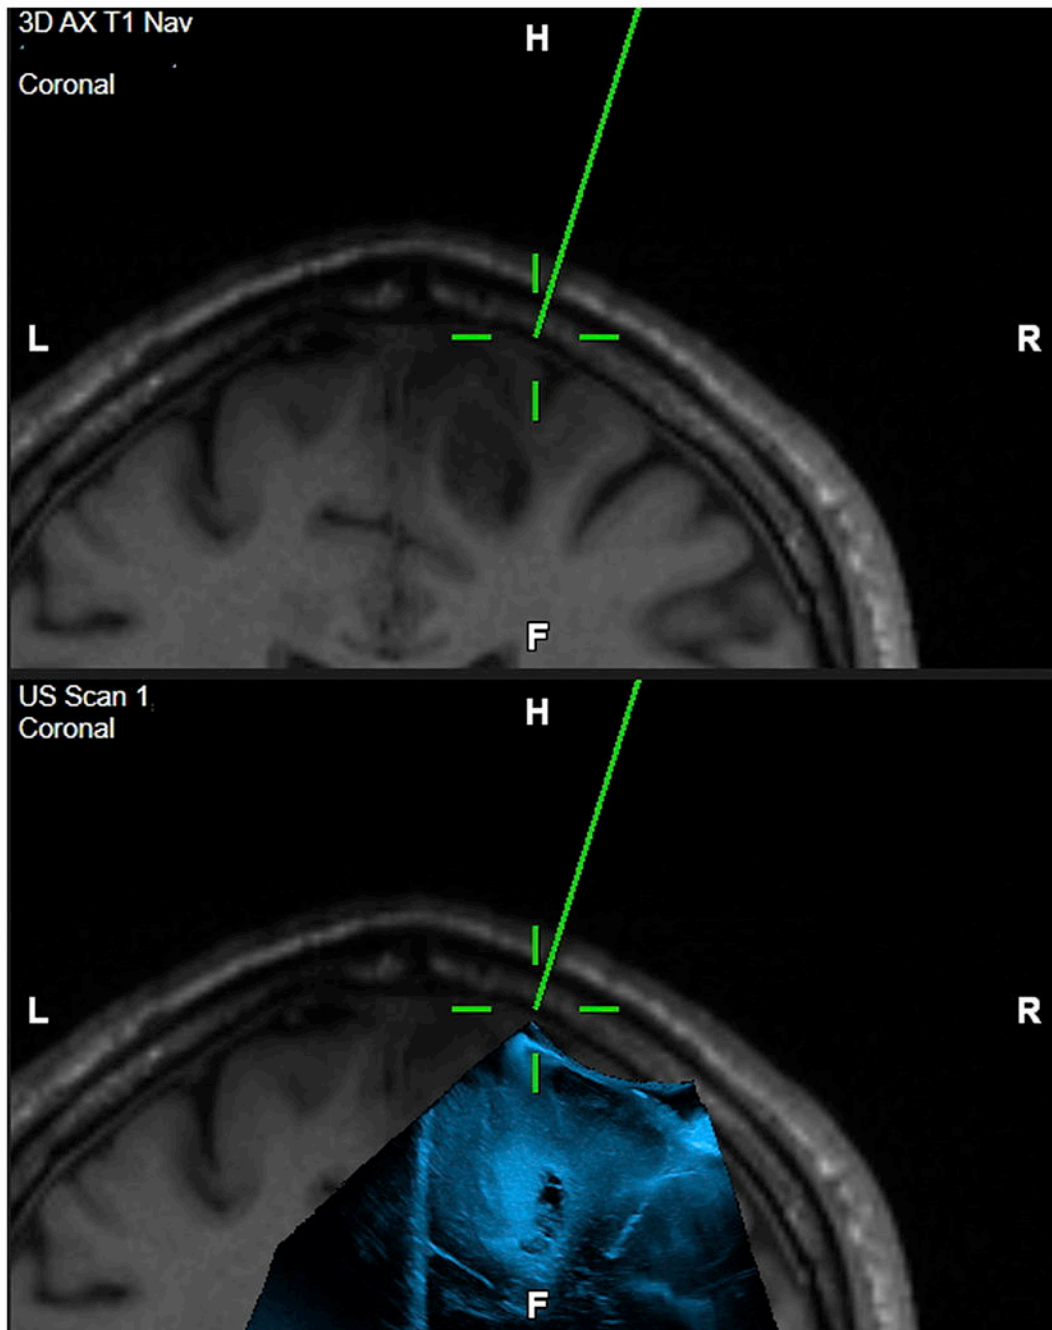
Navigated iUS fused to a preoperative T1-weighted MRI image of a glioma. Navigated iUS allows for accommodation of brain shift showing shift of the hyperechoic tumor relative to the registered preoperative MRI.
